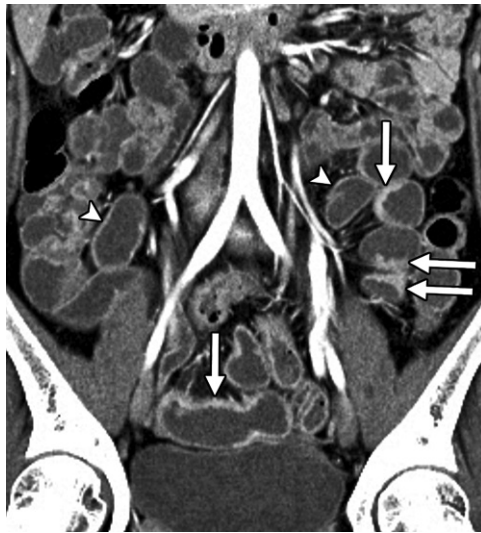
Mild wall thickening (3–5 mm). Coronal contrast-enhanced CT enterographic image with neutral oral contrast material shows mild bowel wall thickening, with asymmetric mural hyperenhancement along the mesenteric border in several small bowel segments (arrows), compared with normal thickness in the uninvolved segments (arrowheads). These findings are consistent with active inflammatory small bowel Crohn disease.
